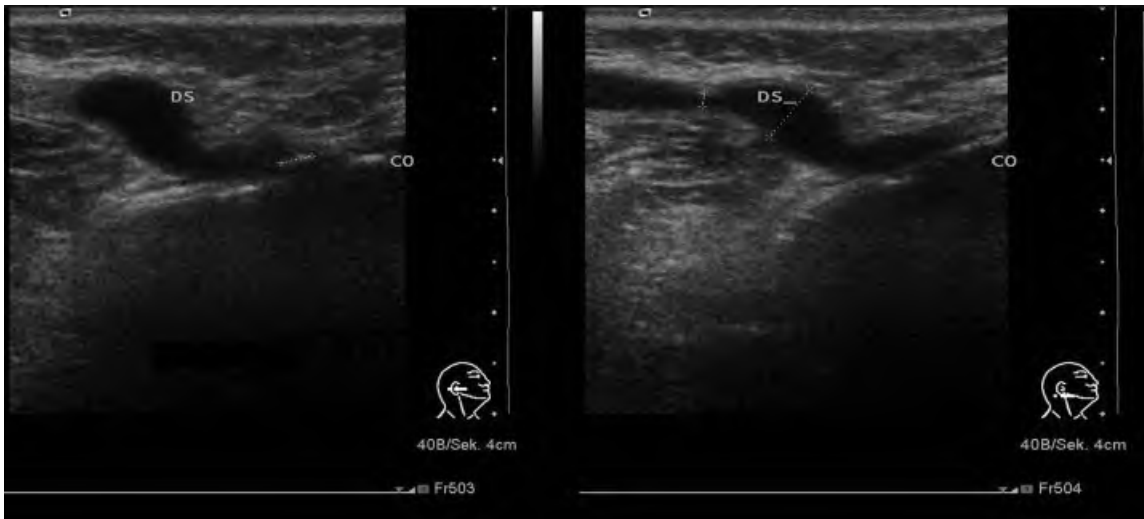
Ascorbic acid stimulation in a patient with Stensen's duct stenosis. Left: Transverse sonogram shows dilated duct near the ostium. Right: Transverse sonogram 60 seconds after ascorbic acid application shows the entire duct and detects a second narrowing (and calipers) delineated. Abbreviations: DS, Stensen's duct, CO, oral cavity.
